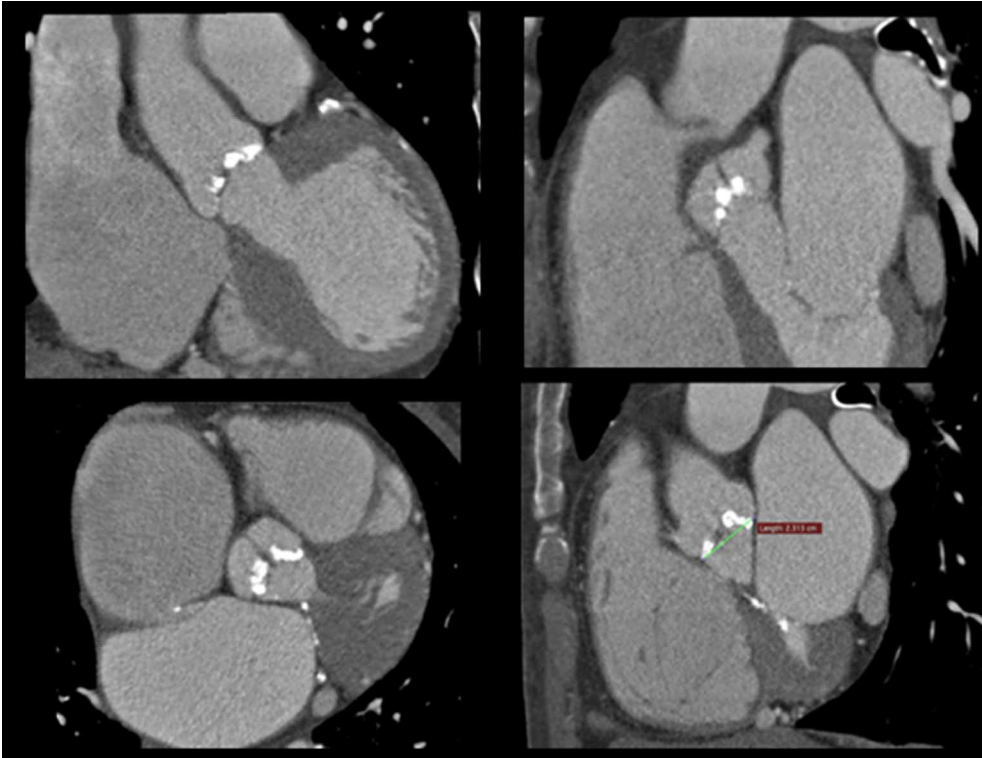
Multi-slice enhanced computed tomography images showing the aortic valve cusps and the first tract of the ascending aorta, with associated presence of extensive valvular calcifications.
